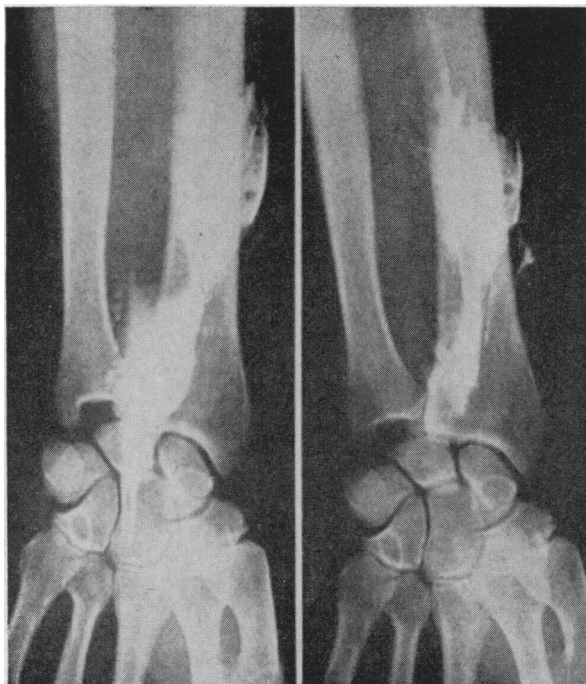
Left, roentgenogram after injection of the sheath of the median nerve with lipiodol with the wrist held in extension. In this position the solution flowed freely into the palm of the hand. Right, roentgenogram after injection of the sheath of the median nerve with lipiodol with the wrist held in acute palmar flexion. The solution is arrested at the level of the transverse carpal ligament. (Used by permission of *Surgery, Gynecology and Obstetrics*).
